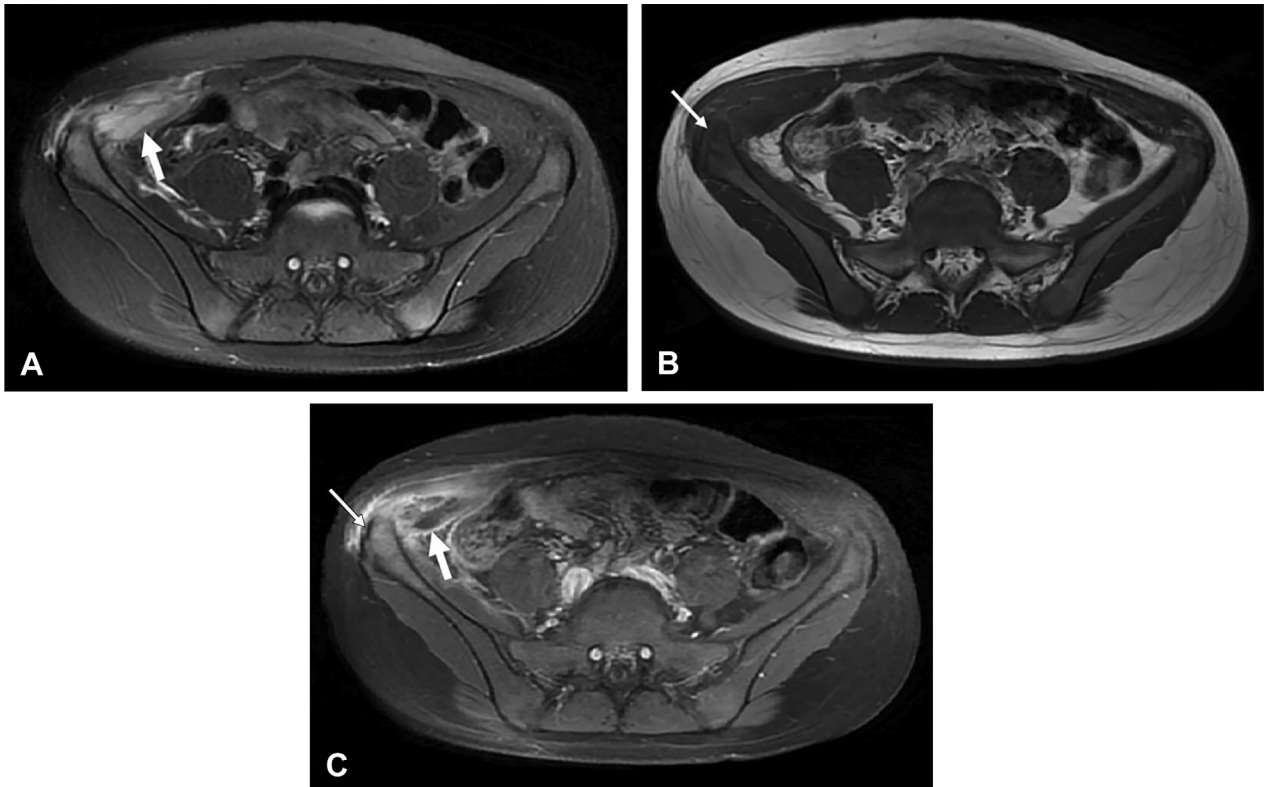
Findings of magnetic resonance imaging, suggesting pyomyositis of the right transversus abdominis muscle with concomitant osteomyelitis of the adjacent ilium. (A) Axial fat-suppressed T2-weighted image shows fluid collection with swelling in the muscle (thick arrow). (B) Axial T1-weighted image shows decreased signal in the adjacent ilium (thin arrow). (C) Axial contrast-enhanced fat-suppressed T1-weighted image shows inhomogeneous enhancement, suggesting an intramuscular abscess (thick arrow). Mild enhancement is also seen in the adjacent ilium (thin arrow), and is considered the osteomyelitis.
